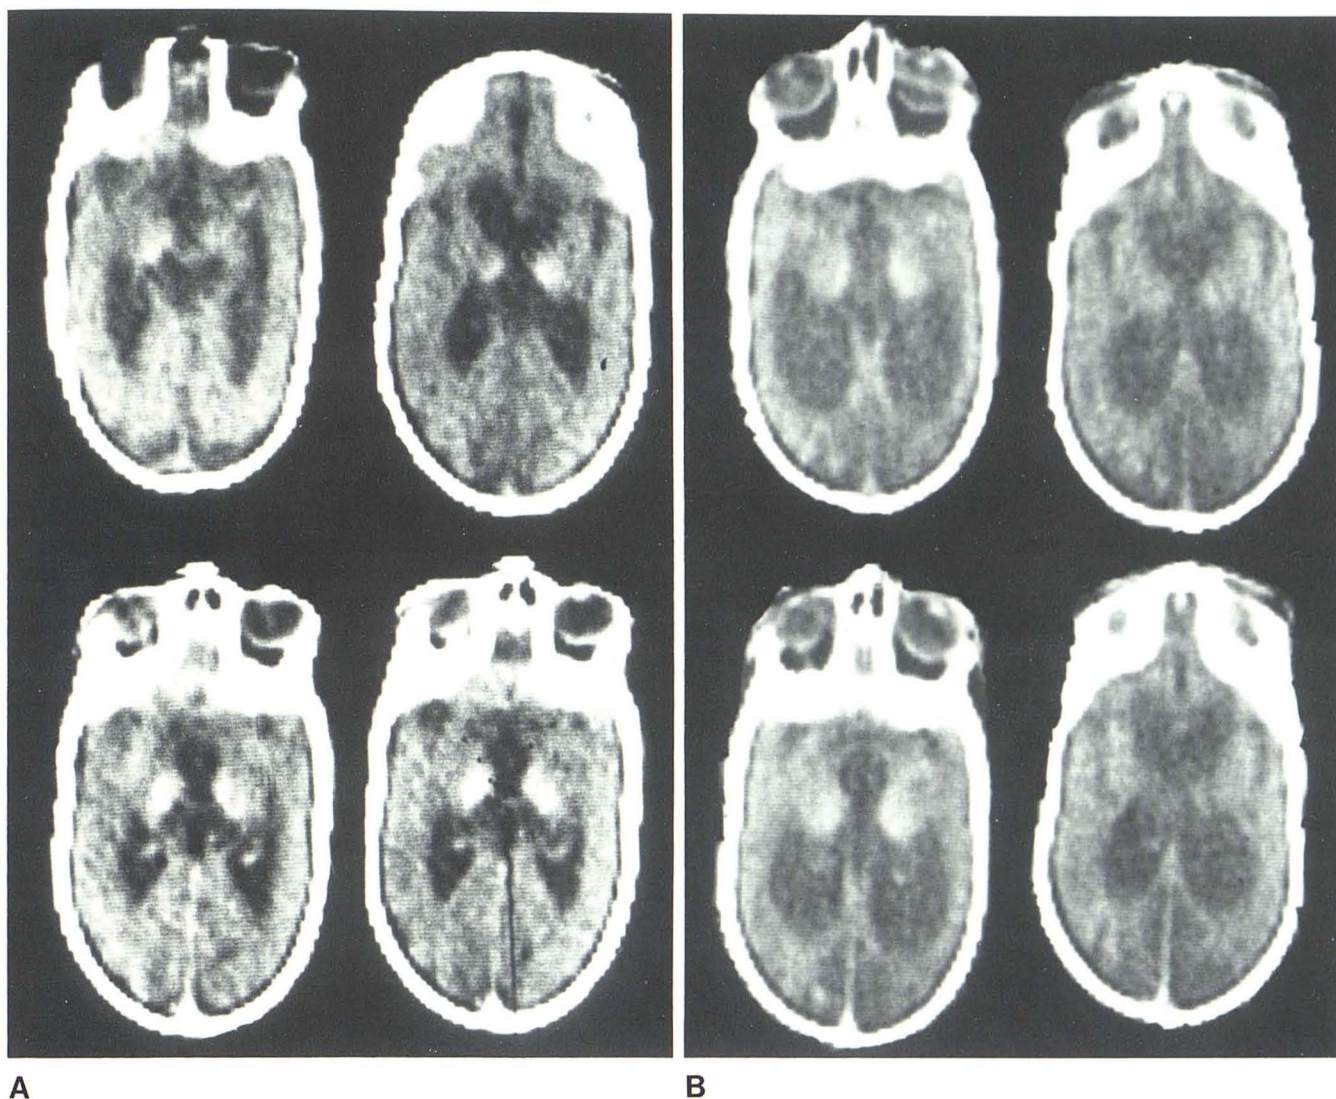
Case A, Pre- (top) and post- (bottom) contrast CT scans with the same window level (50) and window width (100) at 3 (A) and 16 (B) months after perinatal brain hypoxia. High density of thalami, which enhanced after contrast infusion, had become less pronounced 16 months after hypoxic insult. (A is reprinted from [1]).
